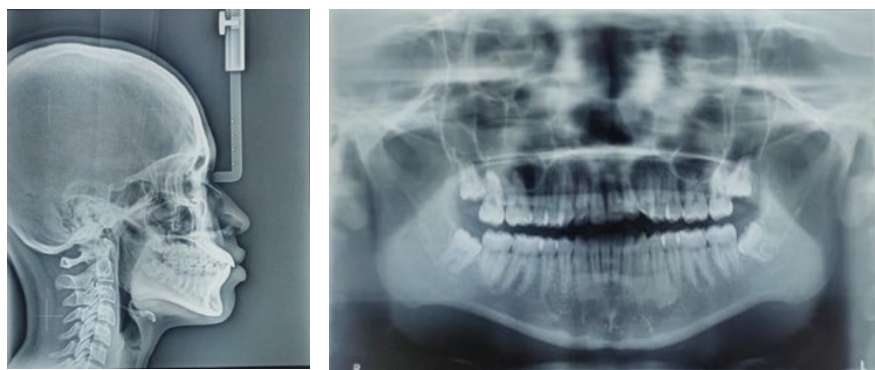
Showing Lateral cephalogram and OPG radiographs.
